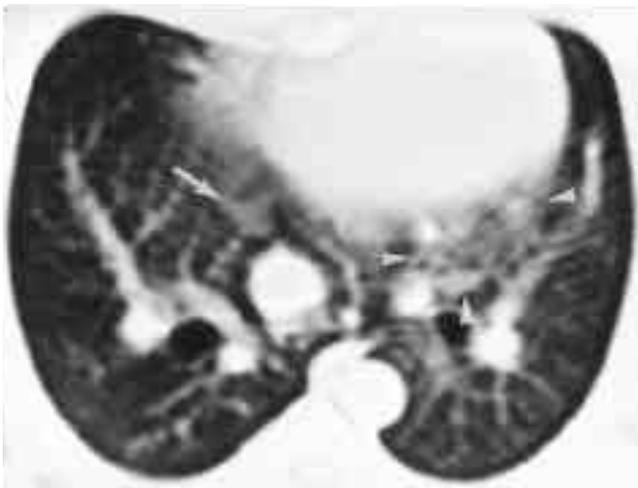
CT scan obtained three day after embolization
